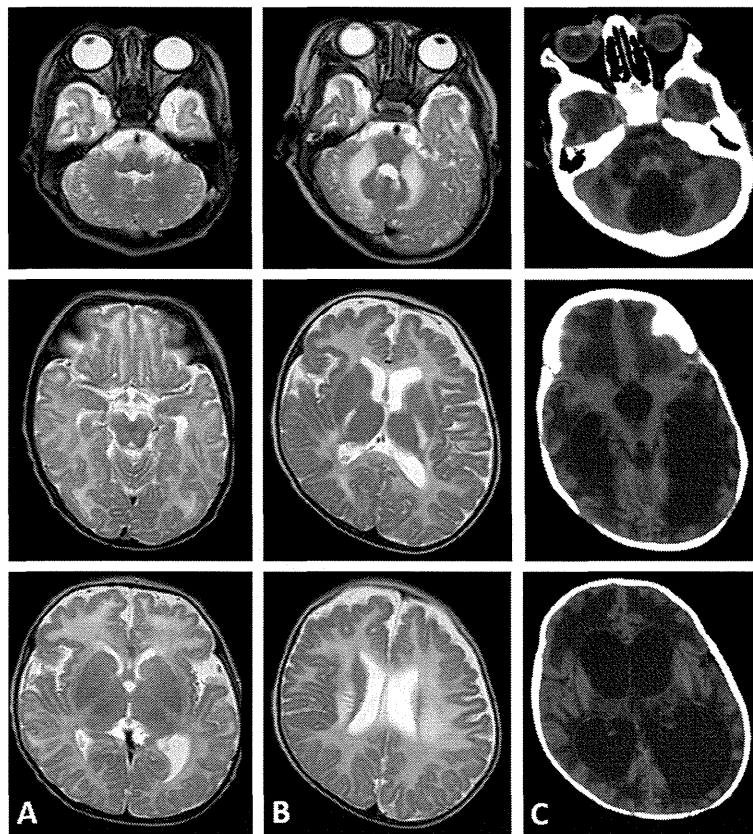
Magnetic resonance image (MRI) at the age of 2 months (A) shows cerebellar cysts (A, top), bilateral symmetrical lesions in the brainstem (A, middle), pachygyria, and T2-hyperintensity in white matter, predominantly in the frontal lobes (A, bottom). An MRI at 4 months of age indicated T2-hyperintensity extending into the middle cerebellar peduncles, posterior limb of the internal capsule, and the corona radiata (B). A brain computed tomography scan at 14 months of age showed severe hydrocephalus, widespread hypodensity of white matter, and extensive cerebral atrophy (C).
